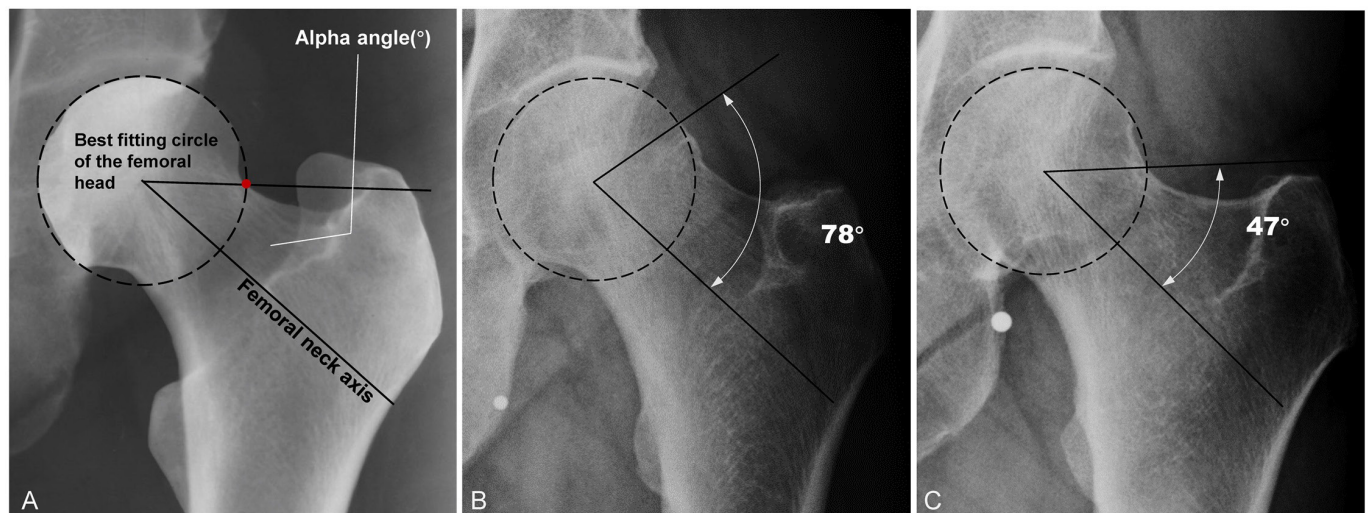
Measurement of the alpha angle on anteroposterior radiographs. (A) The alpha angle is the angle between the femoral neck axis (which passes through the centre of the femoral head and the femoral neck) and a line connecting the femoral head centre and alpha point (red point), where the contour of the femoral head-neck junction begins to leave the best-fitting circle of the femoral head; (B) hip with an alpha angle of 78° ; (C) hip with an alpha angle of 47° .
